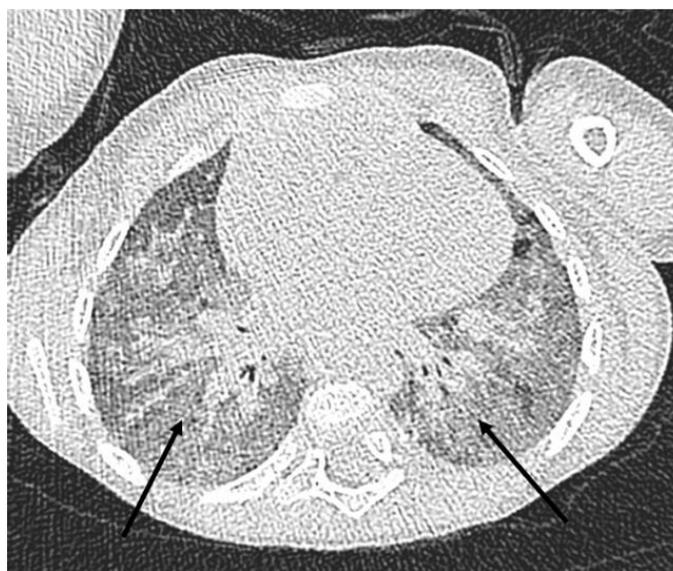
Non-contrast CT scan of a 3 year old boy with idiopathic pulmonary haemosiderosis (IPH). Dose length productivity (DLP) = 4, CTDI vol = 0.29, mAs= 28-30 ms, kVp=100 tube energy and slice thickness= 10mm. The transverse plane shows patchy areas of ground-glass opacity, despite the confounding factor of being taken in the expiratory phase. The ground-glass opacity has a non-specific appearance.
